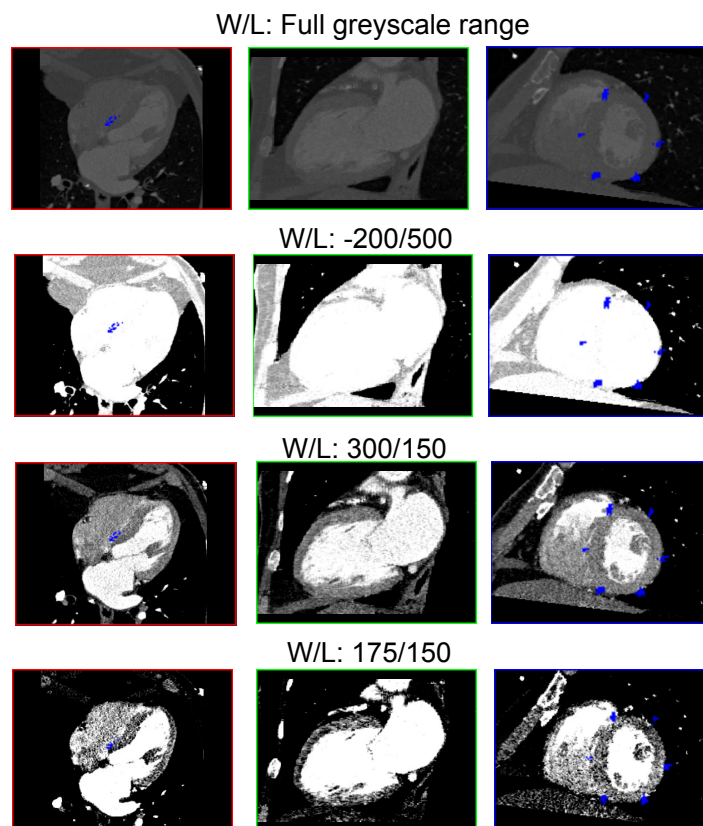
Different window/level (W/L) pairs applied to CT myocardial perfusion image. From top to bottom: no specific W/L applied, W/L usually applied for enhanced lung visualization, W/L=300/150, used as a starting point for myocardial perfusion assessment and W/L=175/150.
